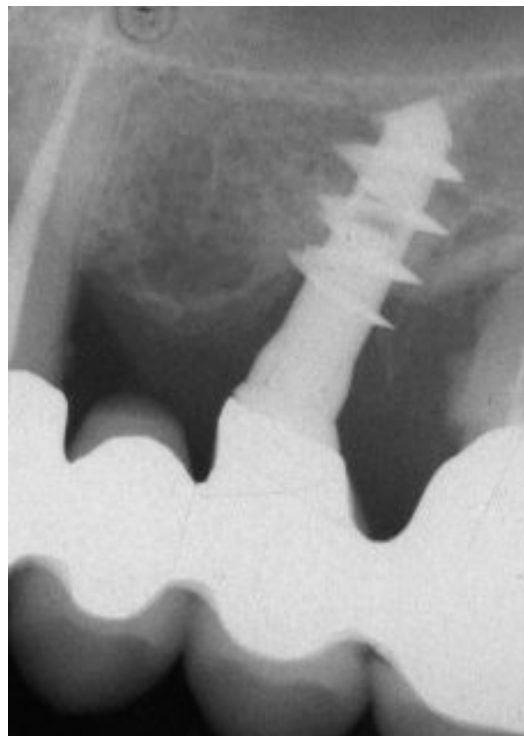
Periapical X-ray before implant retrieval.
